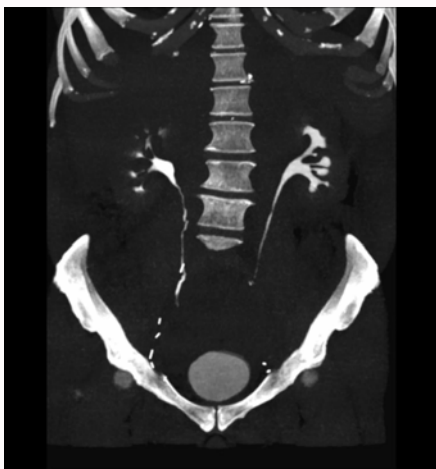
CT scan at 8 weeks of acute episode, without extravasation.
